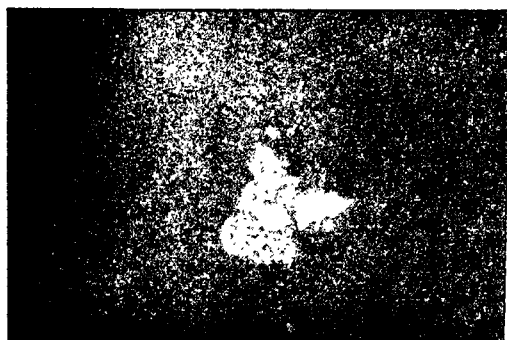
Roentgenogram of the fragmented pancreatic calculus after removal.
